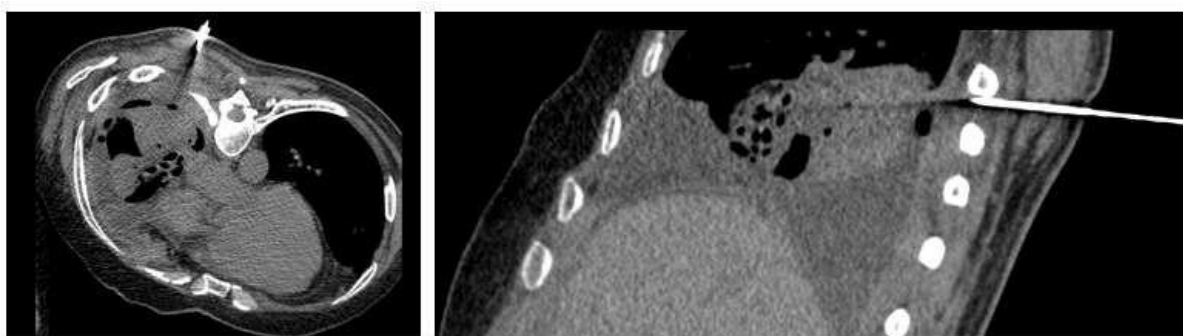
CT-guided transthoracic biopsy using a Quick-Core needle directed into the right posterobasal pulmonary mass, performed under real-time imaging. A small right pleural effusion is present, and no post-procedural pneumothorax or pneumomediastinum is identified
